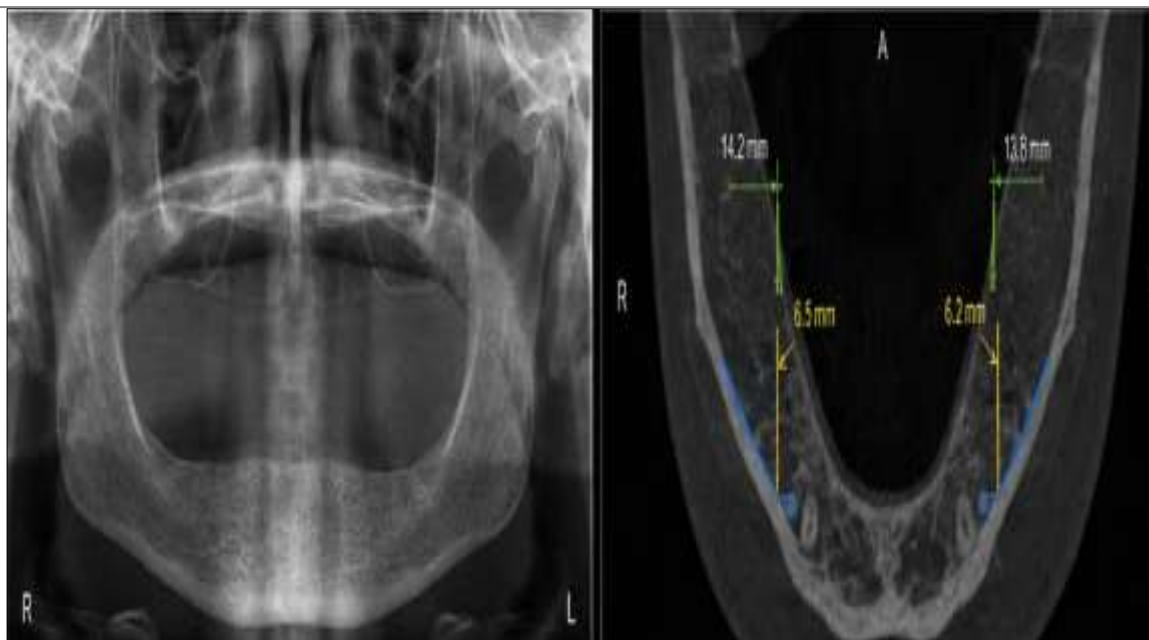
Digital x-ray image of CBCT
